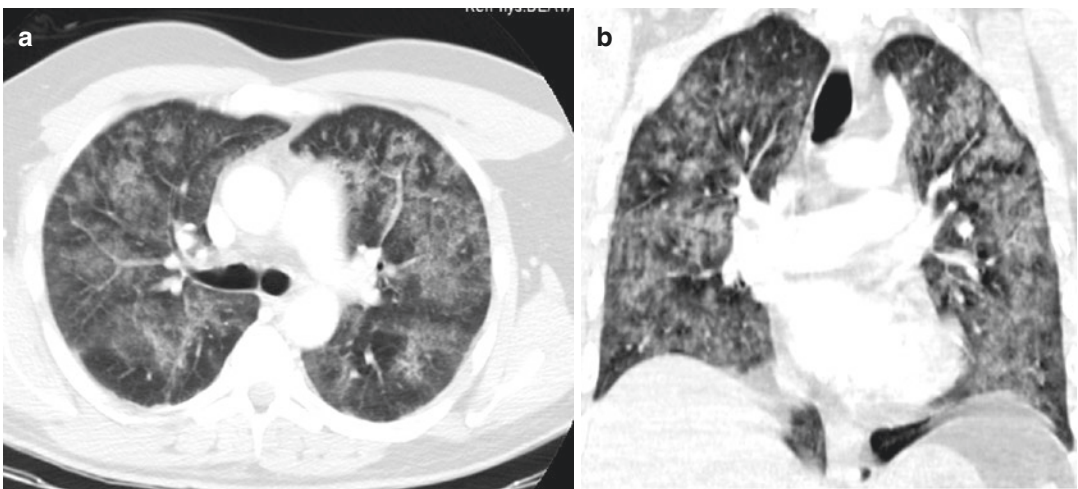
(a) Axial CT scan; (b) coronal reconstruction. Pedestrian-invested: after 3 days, “cottony” opacifications with spared subpleural regions; signs suggestive of adipose embolism in ARDS
